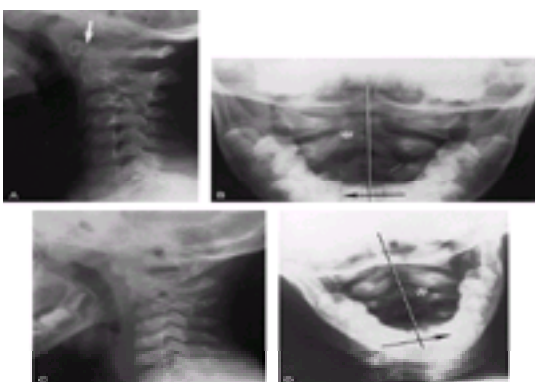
Torticollis (wryneck). A. Lateral cervical radiograph with C-2 cocked forward on C-3 and normal prevertebral space (*arrow*). B. Anteroposterior (AP) view demonstrating spinous process of C-2 (*) on the same side of the midline as the mandible points. C. Difficult to interpret lateral cervical spine because of the rotation effect of torticollis. D. AP view demonstrating spinous process of C-2 (*) on the same side of the midline as the mandible points. (Reprinted with permission from Swischuk L. *Emergency Radiology of the Acutely Ill or Injured Child*. 2nd ed. Baltimore: Williams & Wilkins, 1986:588.)
